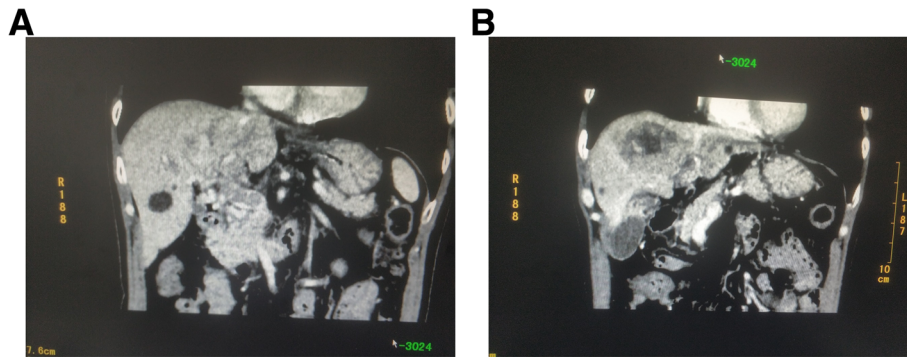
Representative computed tomography scan images before the operation. a. White circle showing the portal vein tumor thrombus, and that the portal vein main trunk was invaded; this was classified as grade VP4. b: White circle denoting the tumor located in the liver section IV; the approximate diameter is 5 cm. The tumor showed enhancement in the arterial phase and no enhancement in the portal and delayed phases
